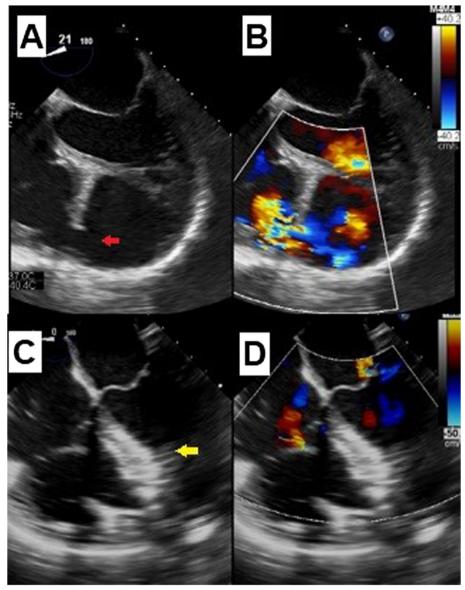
Intra-operative TEE, demonstrating a color compare for 4-chamber view. Panels A and B show an apical PIVSR (red arrow) with left to right shunt. Panels C and D show the post-surgical outcome showing a septal patch (yellow arrow) with no residual shunt. PIVSR, Post-infarction ventricular septal rupture; TEE, Trans-esophageal echocardiography
